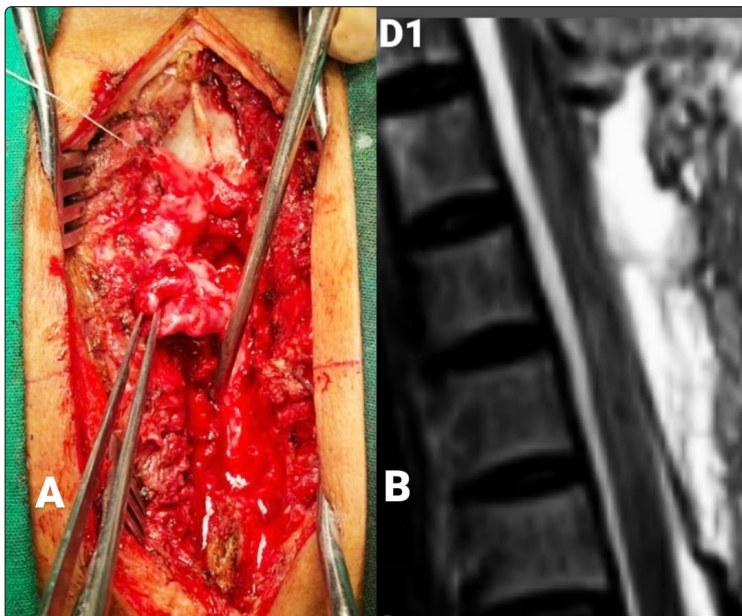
Intraoperative and postoperative MRI. (A) Globular mass with a smooth surface in the extradural space adherent to the dural surface with a definitive plane of cleavage between dura and tumor. (B) Complete excision of lesion with postoperative changes.
